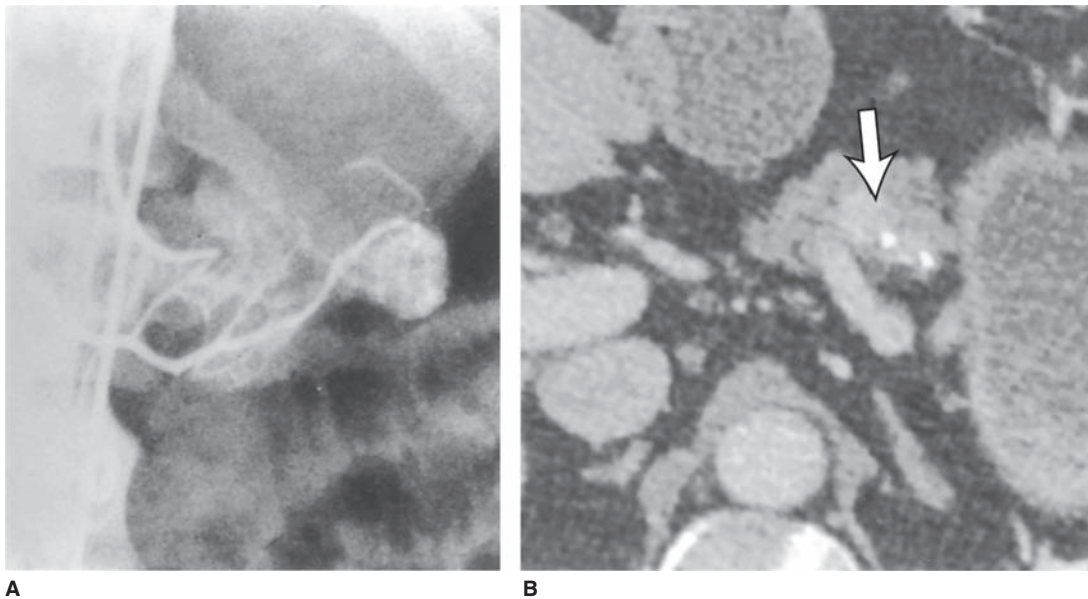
Localization studies demonstrating an insulinoma. A. Arteriographic demonstration of an insulinoma. Selective injection into the specific dorsal pancreatic artery demonstrates the tumor precisely. B. Insulinoma with triphasic enhancement on CT. The mass in pancreatic body (*arrow*) demonstrates early and prolonged enhancement with washout during the portal venous phase; note that the maximal difference in enhancement between tumor and normal pancreas occurs during pancreatic phase (shown). (*A* from Edis AJ, McIlrath DC, Van Heerden JA, et al. Insulinoma—current diagnosis and surgical management. *Curr Probl Surg.* 1976;13:1–45, with permission from Elsevier; *B* from Ros PR, Mortelé KJ. Imaging features of pancreatic neoplasms. *JBR-BTR.* 2001;84:239–249, with permission.)
